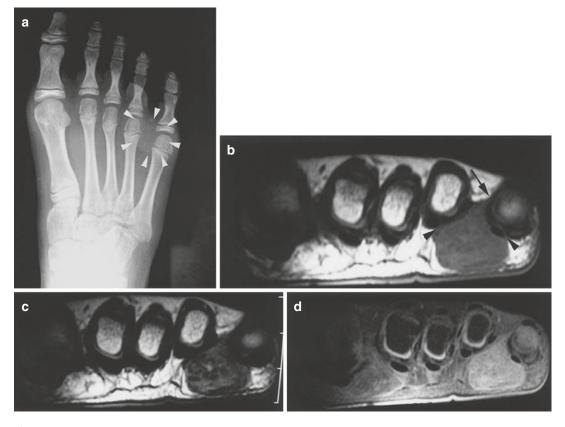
(a–d) Calcifying aponeurotic fibroma. A 10-year-old girl presented with a firm, elastic, hard mass at the plantar side of the foot. (a) Radiographs revealed faint calcification in the mass (*arrowheads*) (b) T1-weighted MR image revealed an isointense lesion adherent to the flexor tendon and invading the interdigital
